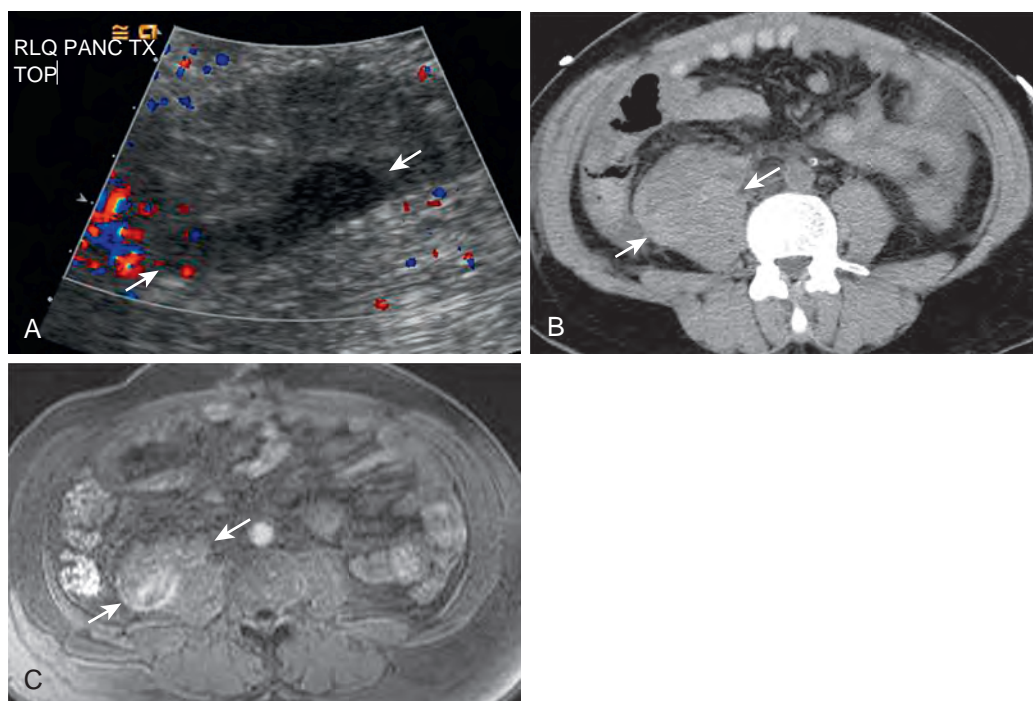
Peripancreatic hematoma in a 44-year-old man after anticoagulation for partial splenic and superior mesenteric vein thrombosis in PAK transplantation. A. Longitudinal US shows a nonspecific hypoechoic avascular collection (arrows) with internal echoes posterior to the transplant pancreas and anterior to the right psoas muscle. B. Axial unenhanced CT demonstrates hyperdensity within the collection (arrows), suggestive of hematoma. C. On fat-suppressed T1-weighted MR image, there is characteristic high signal within the collection (arrows), confirming presence of blood products. (From Vandermeer F, Manning MA, Frazier A, et al: *Imaging of whole-organ pancreas transplants*. *RadioGraphics* 32:411–435, 2012.)
